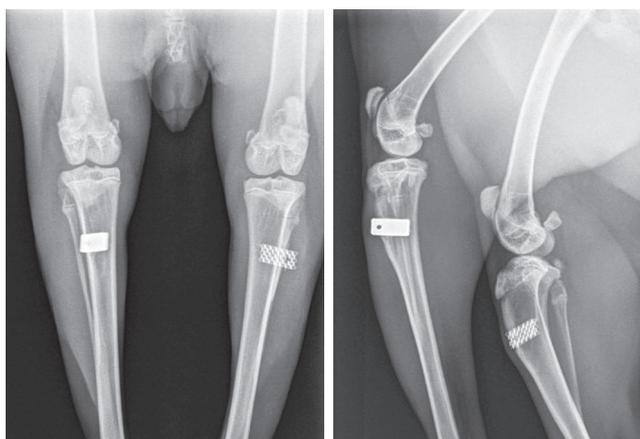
AP and lateral X-rays on day 90 after implantation. No radiolucency observed around the implants, surrounding bone without any pathological changes
